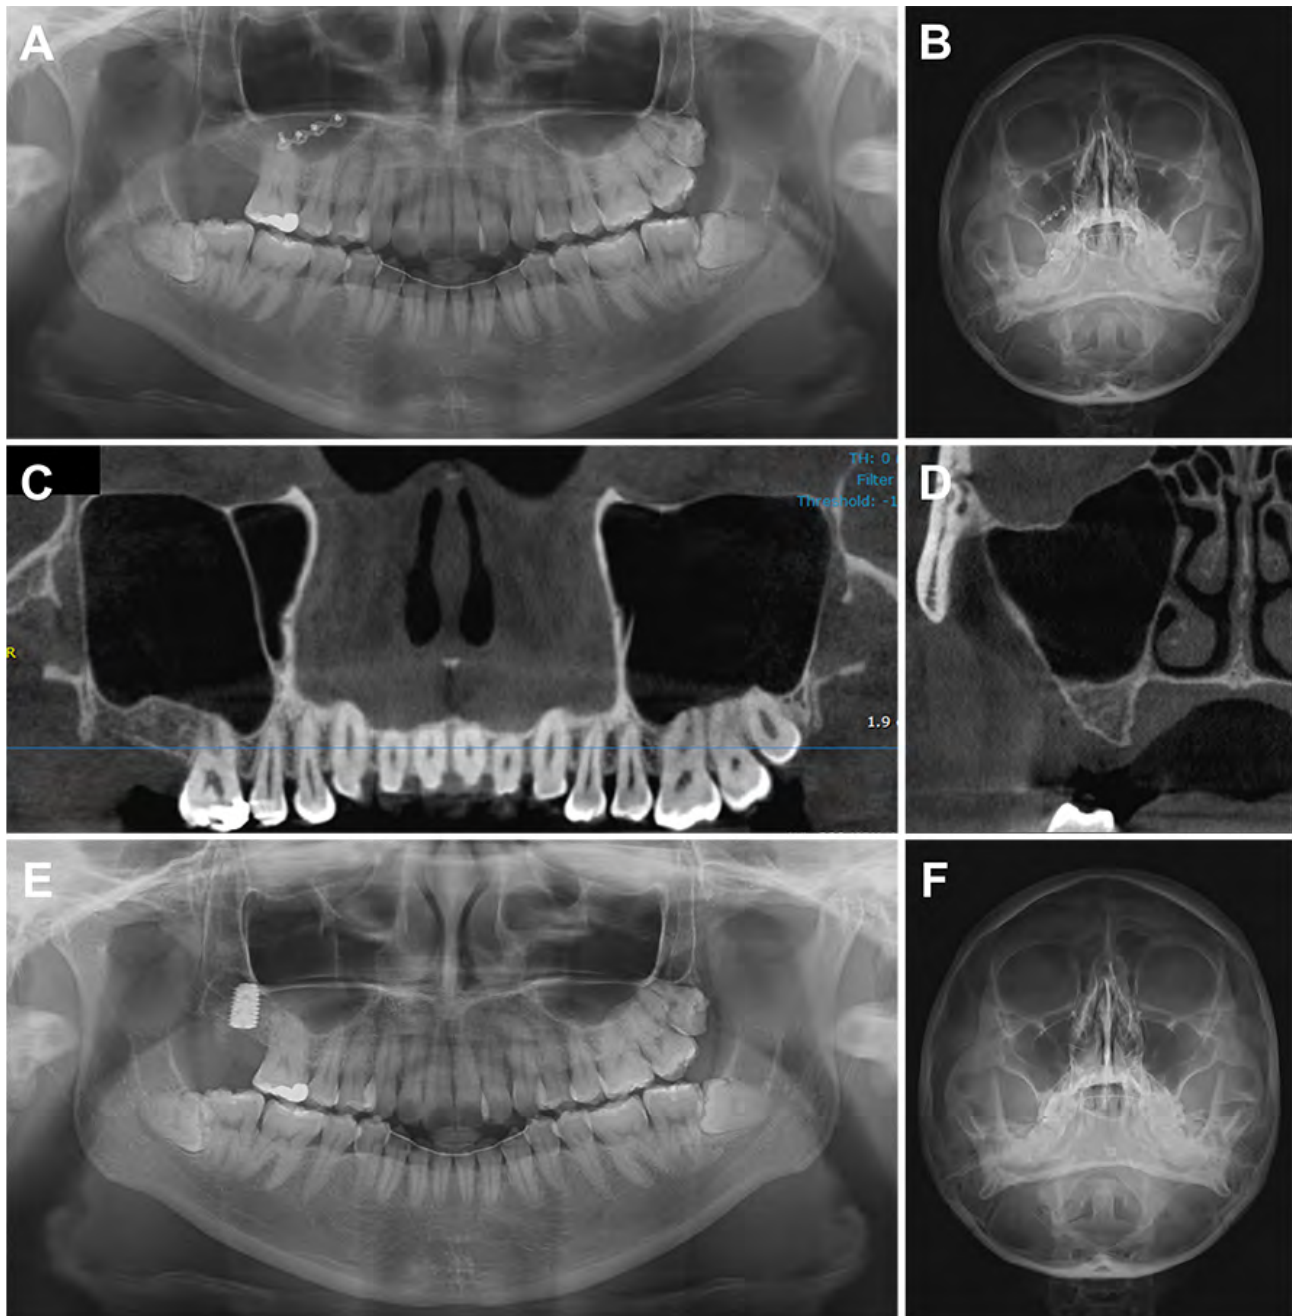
Postoperative radiographic examination. (A, B) 4 months after modified endoscopic-assisted sinus surgery; (C, D) Immediately before implant surgery; (E, F) immediately after implant surgery.
